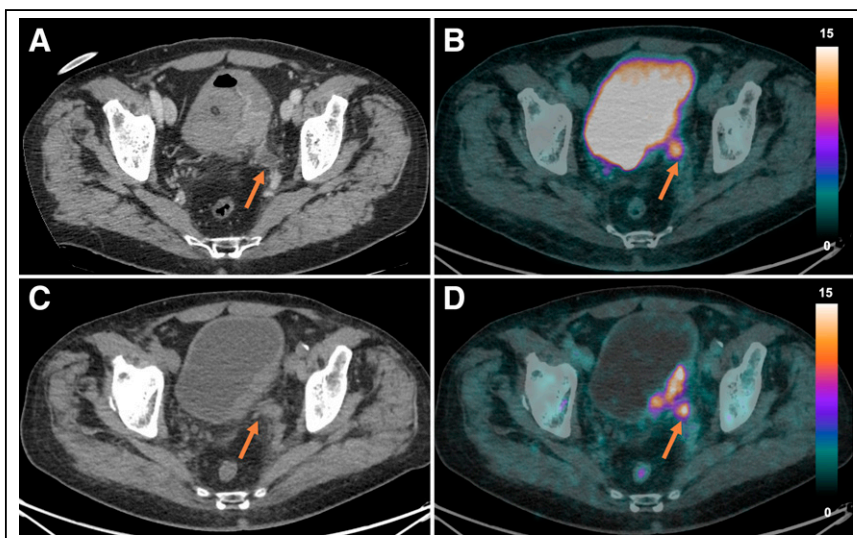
Evaluation of disease extension on ^{18}F -FDG PET/CT (B), ceCT (A), and $^{64}\text{CuCl}_2$ PET/CT (C and D). Ureter invasion by primary tumor was suspected on ceCT images (A, arrow). On ^{18}F -FDG examination, bladder wall was poorly evaluable; hyperactive spot in distal left ureter appeared as mere dilation (arrow). On $^{64}\text{CuCl}_2$ PET/CT, ureteral area was identified as infiltrated by disease (C and D, arrows). Uptake intensity is expressed in SUV.
